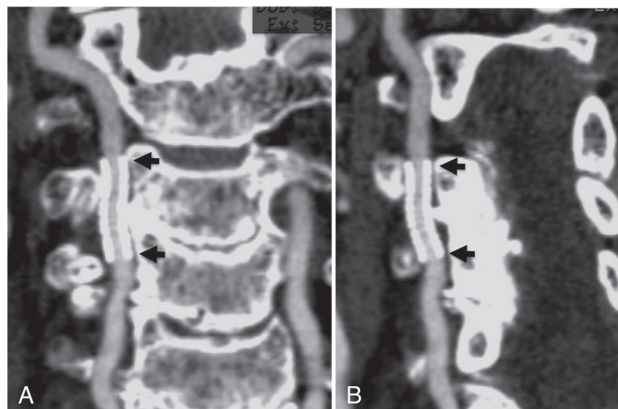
Computed tomography (CT) angiography with multiplanar reconstruction 4 years after the procedure shows the stent-graft fully patent without deformation. Complete exclusion of the aneurysm was observed during the follow-up period. A: Anteroposterior view, B: oblique view.
